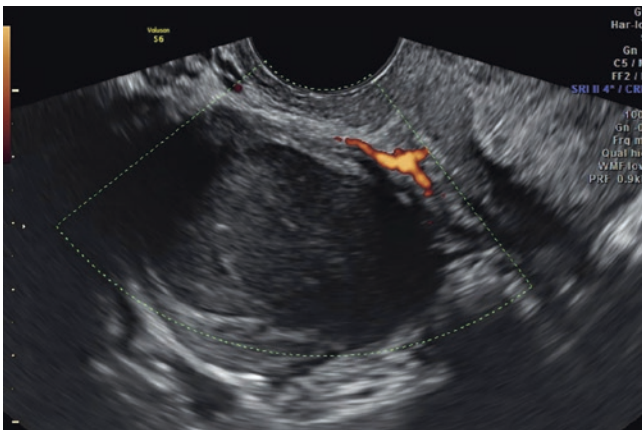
Transvaginal sonogram of the right ovary: Endometriotic cyst with low vascularization on color Doppler sonography
